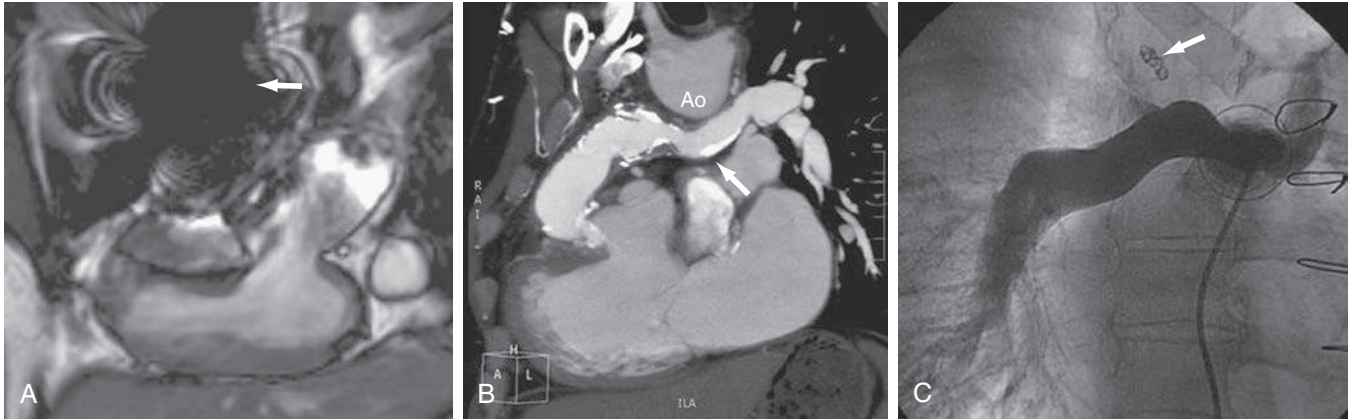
A, Magnetic resonance imaging (MRI) of a patient with dextrocardia and pulmonary atresia. Because of prior coiling of collaterals in the right upper chest, there is signal loss from the metal coils (arrow), rendering that portion of the image uninterpretable, and hence impossible to assess the right ventricle (RV)-pulmonary atresia (PA) conduit or the PAs themselves. B, Computed tomography of the same patient, showing the conduit arising from the RV (out of plane) coursing medially towards an interposition graft (arrow) underneath the aortic arch (Ao) between the right pulmonary artery (RPA) and left pulmonary artery (LPA). Both the conduit and the interposition graft are heavily calcified with several areas of stenosis. C, Pulmonary angiography of the same patient. The catheter runs through the conduit, whose distal end is marked with a radiopaque circle. Contrast is seen in the LPA and RPA. Note the absence of a branch to the right upper lobe, which was instead fed via a major collateral from the right subclavian artery (not shown). The coils which cause image obliteration by MRI (A) are also visible (arrow). Ao, Aortic arch.
